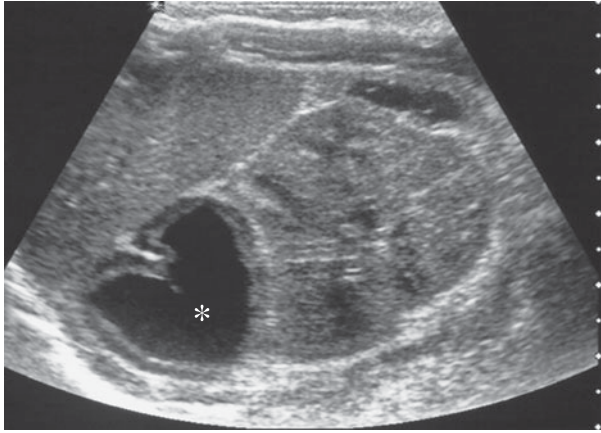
Ultrasound adrenal hemorrhage. Cystic enlargement of the adrenal gland typical of an adrenal hemorrhage (asterisk). (L = liver, K = right kidney.)
